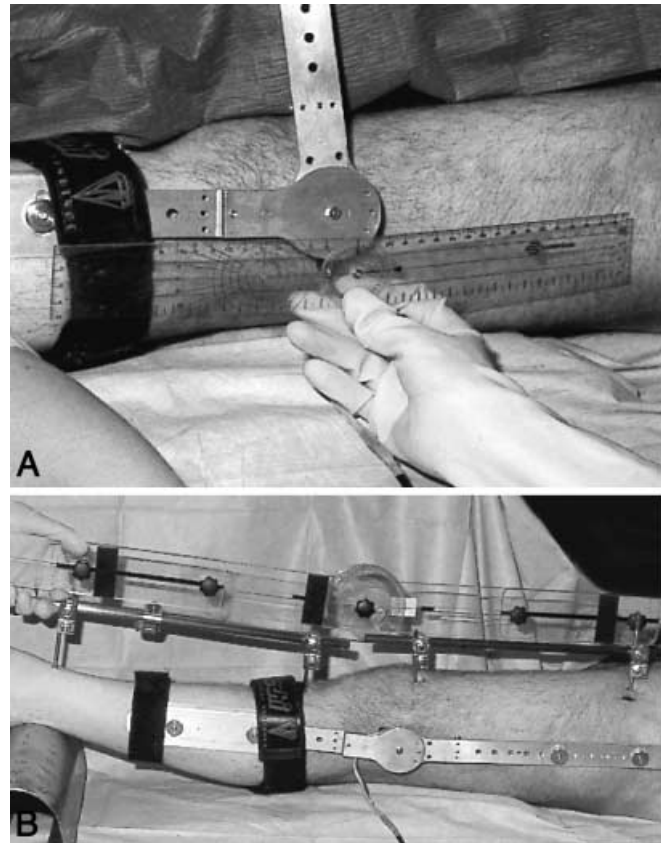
A Goniometric measurements of knee extension. The bars of the external fixation device were covered to avoid bias. An independent observer determined knee extension using the joint line, the distal fibula and the greater trochanter as reference points. B The novel extension measurement device was posted against the anterior tibia and the greater trochanter using anatomic moulds. Aligning the rods of the external fixation device parallel to the axis of rotation of hip, knee and ankle under radiographic control, the reference knee extension angles were determined using a long arm goniometer
